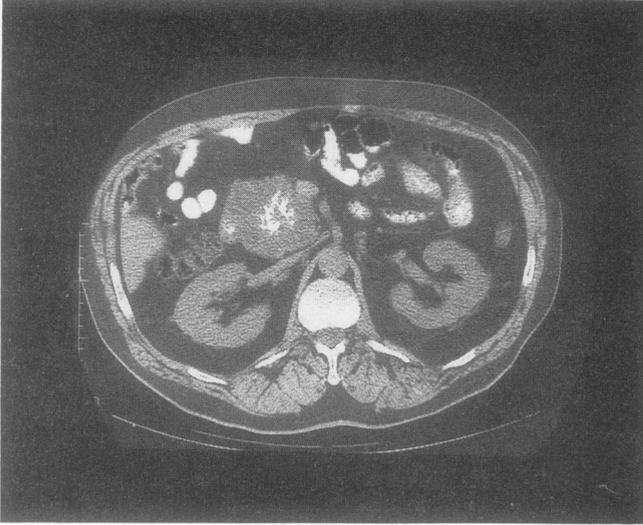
CT scan showing serous cystadenoma of the head of the pancreas. Note the central stellate calcification.
